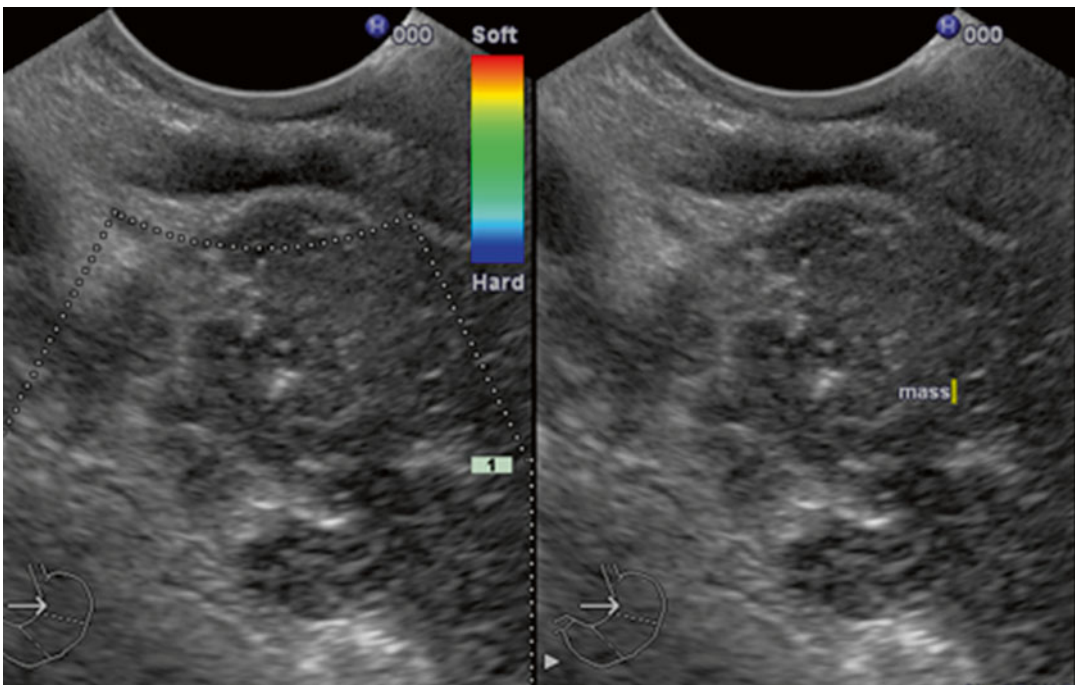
A hypoechoic pancreatic mass in a patient with a final diagnosis of a focal form of autoimmune pancreatitis is shown. Endosonographic findings of echo-poor
